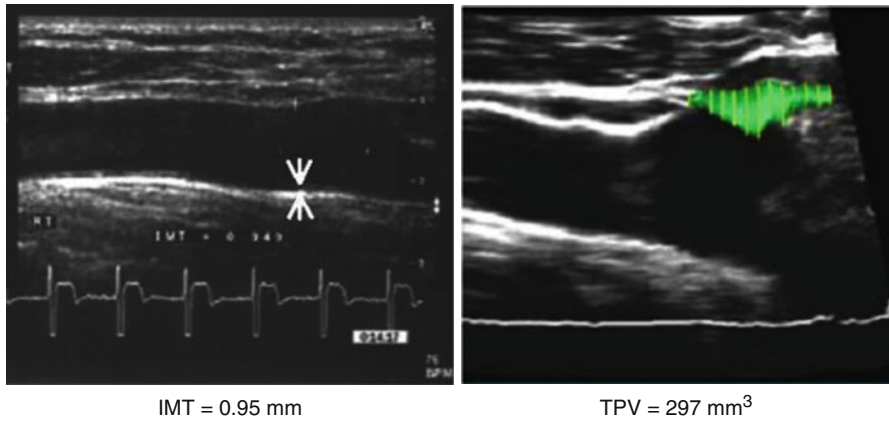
Ultrasound in carotid anatomy. Ultrasound images used for the determination of carotid anatomy in a subject. The panel on the *left* shows an image of the right carotid artery used to determine intima-media thickness (*IMT*), with the *arrows* at the far carotid wall showing where *IMT* was determined. The panel on the *right* shows an image used to determine total plaque volume (*TPV*), with the encircled colored region defining one of the plaques identified (From Pollex et al. [12]. © 2006 ; licensee BioMed Central Ltd; <http://www.cardiovascularultrasound.com/content/4/1/28>)
